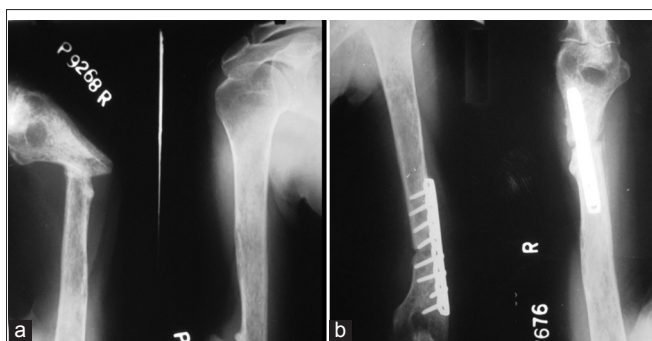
X-ray anteroposterior and lateral views of humerus showing. (a) Atrophic nonunion. (b) Union achieved 7 months following fixation with locking compression plate and bone grafting.
